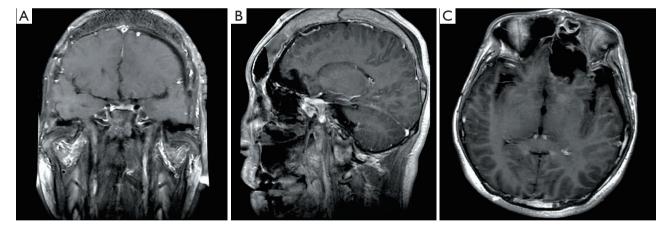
The coronal (A), sagittal (B), and axial (C) planes of post-operative brain and pituitary MRI with GBCAs. It showing the lesions in the anterior cranial fossa and the left side of the pituitary have resolved. MRI, magnetic resonance imaging; GBCAs, gadolinium-based contrast agents.
